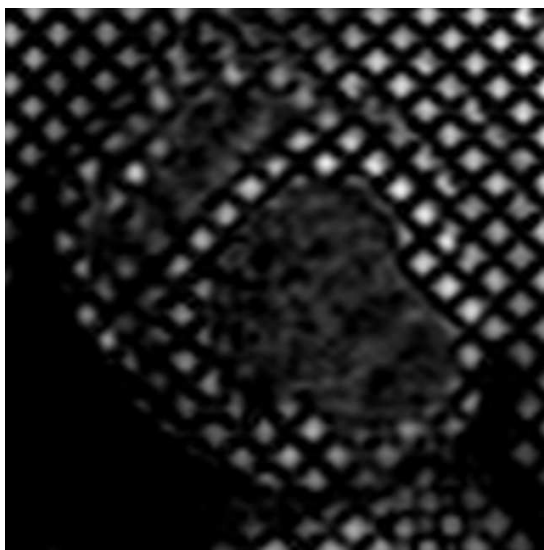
Short axis projection of the Cine MRI and tagged Cine MRI of a healthy subject.
